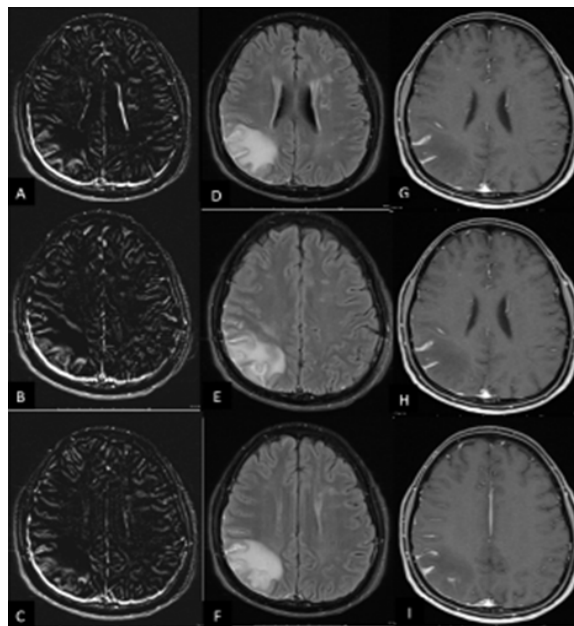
Leptomeningeal enhancement detection using image subtraction A–C, Coregistered pre- /post-contrast 2D-FLAIR subtracted images in the axial plane. D–F, Post-contrast 2D-FLAIR images in the axial plane. G–I, Post-contrast 3D-T1WI images in the axial plane. Owing to the assistance of pre- and post-contrast 2D-FLAIR subtraction images, it was easier to spot a true leptomeningeal contrast enhancement at the right parietal lobe, seen above.
